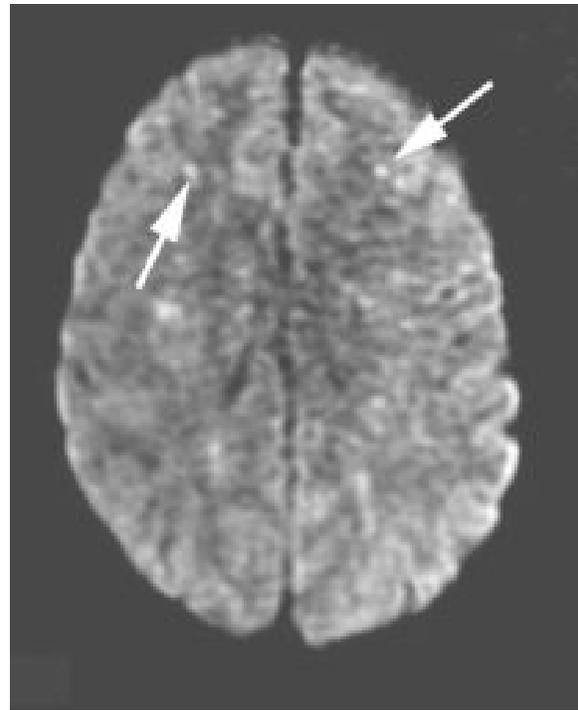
Figure 2 Diffusion weighted images (DWI) showed increased signal intensity signifying restricted diffusion producing a "starfield" appearance (arrow).
